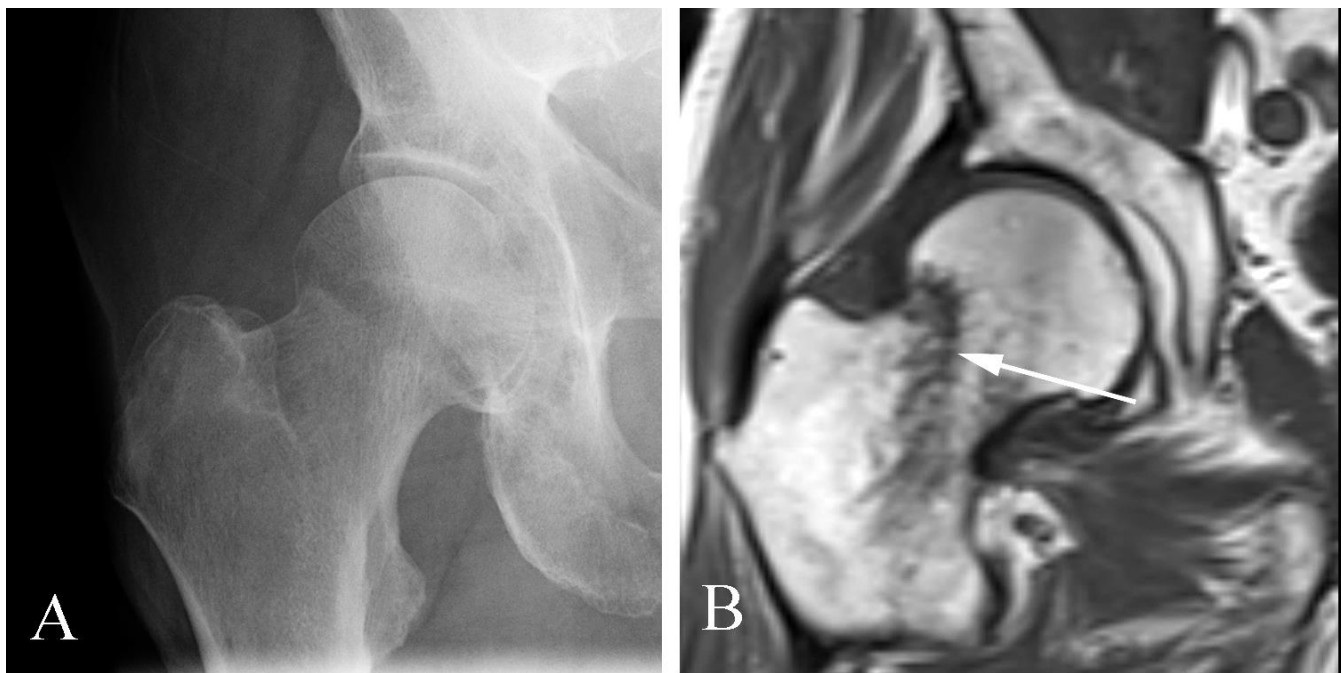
Hip fracture seen on MR in a 94 year old man with persistent pain following trauma. A. AP plain film of the hip shows no fracture. B. Coronal T1 weighted MR study shows a fracture line through the femoral neck (arrow).
